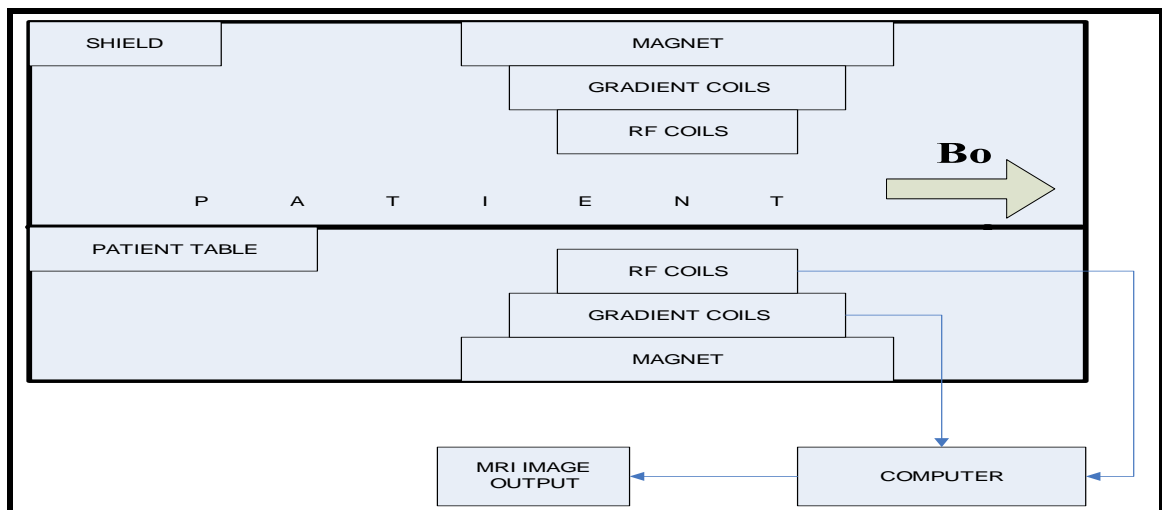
The MRI system.
